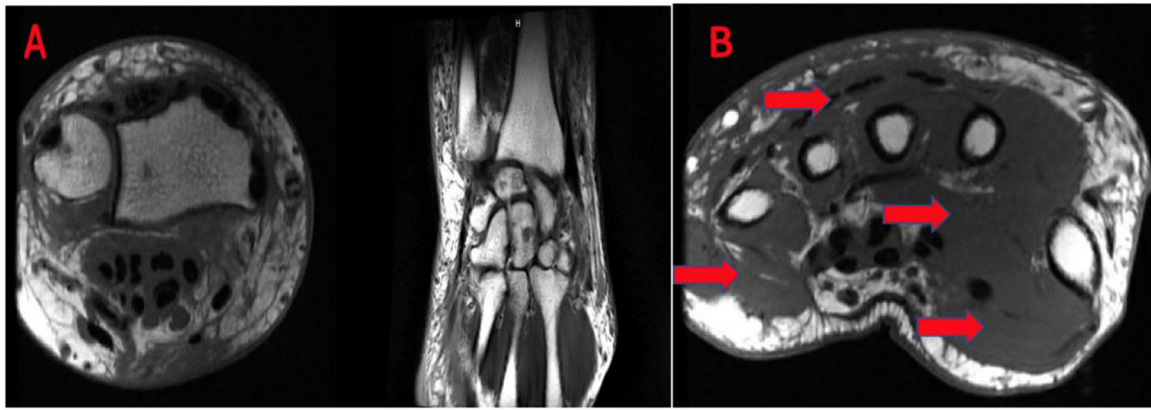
(A) MRI without contrast of right wrist showing diffuse soft tissue swelling in the saphenous tissues and evidence of edema noted in the deep musculature. There was no evidence of any fluid collection, bony edema, or fractures. (B) MRI of right hand showing diffuse soft tissue swelling.
